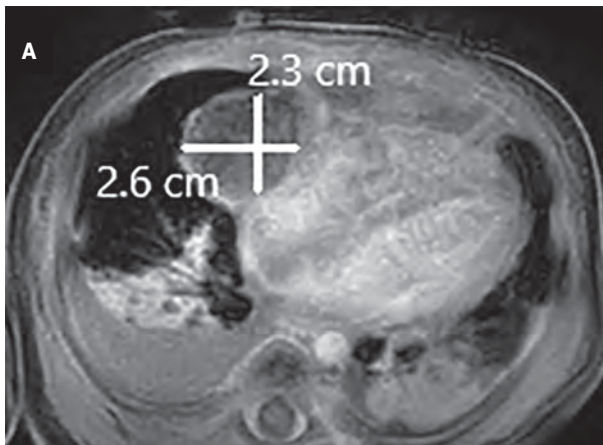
(A) T1 postcontrast axial MRI demonstrates no significant enhancement. (B) Coronal T2 demonstrates hypointense signal.
